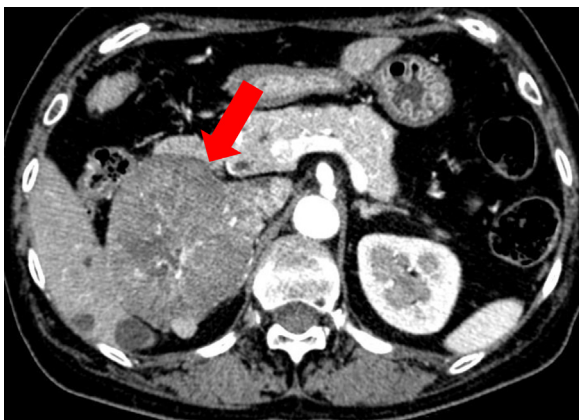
Computed tomography of the 7 cm right adrenal mass (arrow).
